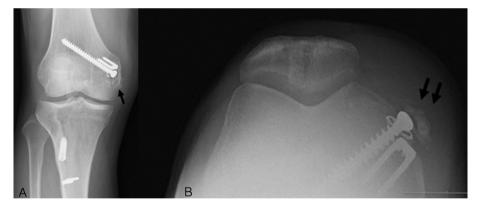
Preoperative knee. (A) Anteroposterior and (B) Merchant radiographs. Calcifications (Black arrow) were deposited over the cancellous screw that was fixed on medial aspect of the medial femoral condyle.
